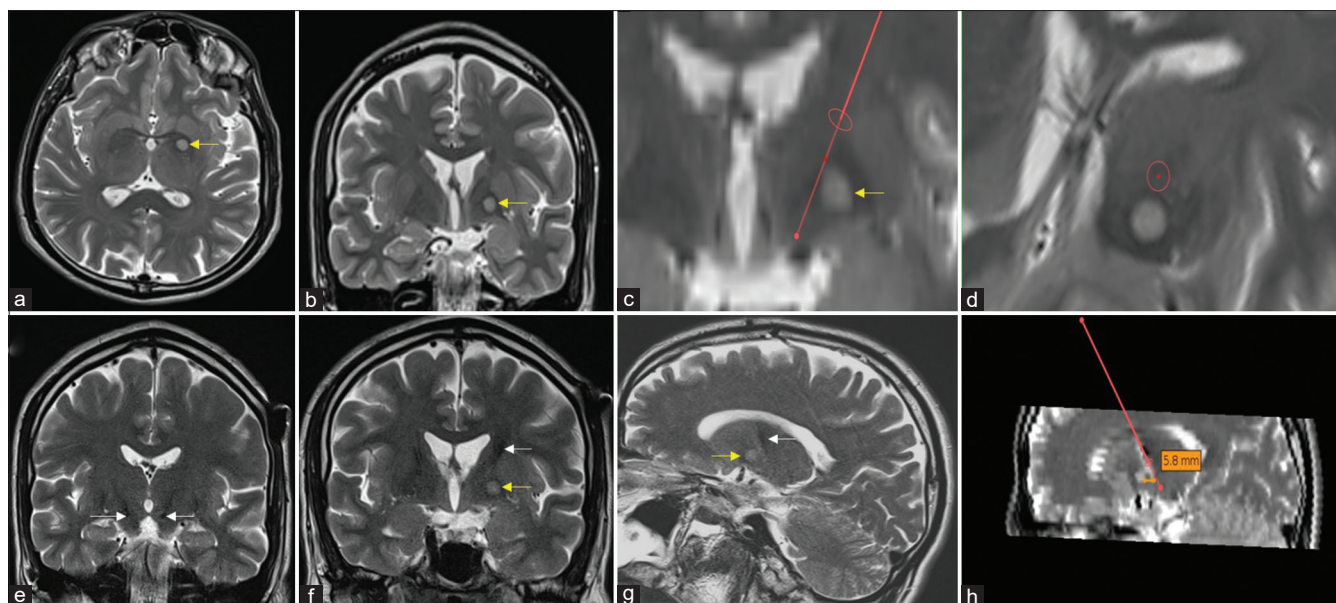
(a) Hyperintense lesion in axial and (b) coronal pre-DBS T2-MRI at left GP. (c) Planned trajectory abutting the lesion (d) planned trajectory in probe's eye view, (e) Post-operative MRI showing, STN tip in the subthalamic area (f) 2-year follow-up scan highlighting trajectory of the DBS lead (white arrow) and the lesion (yellow arrow) (g) T2-sag MRI at 2-year follow-up highlighting stable lesion size and lead trajectory, (h) sagittal plane showing the distance between the final lead trajectory and GP lesion margin
